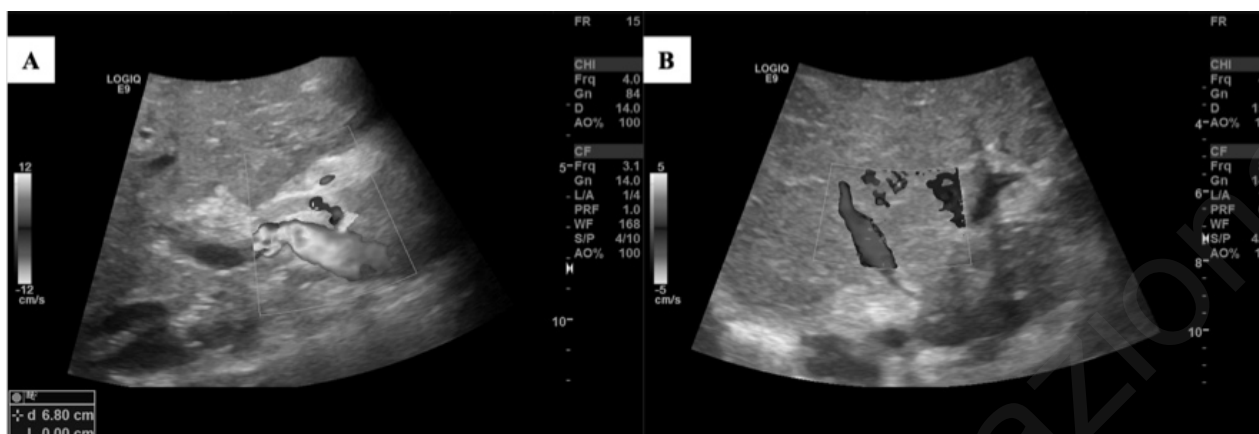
Ultrasound findings of vascular thrombosis of liver graft. A) Hepatic artery thrombosis; B) Portal vein thrombosis.
